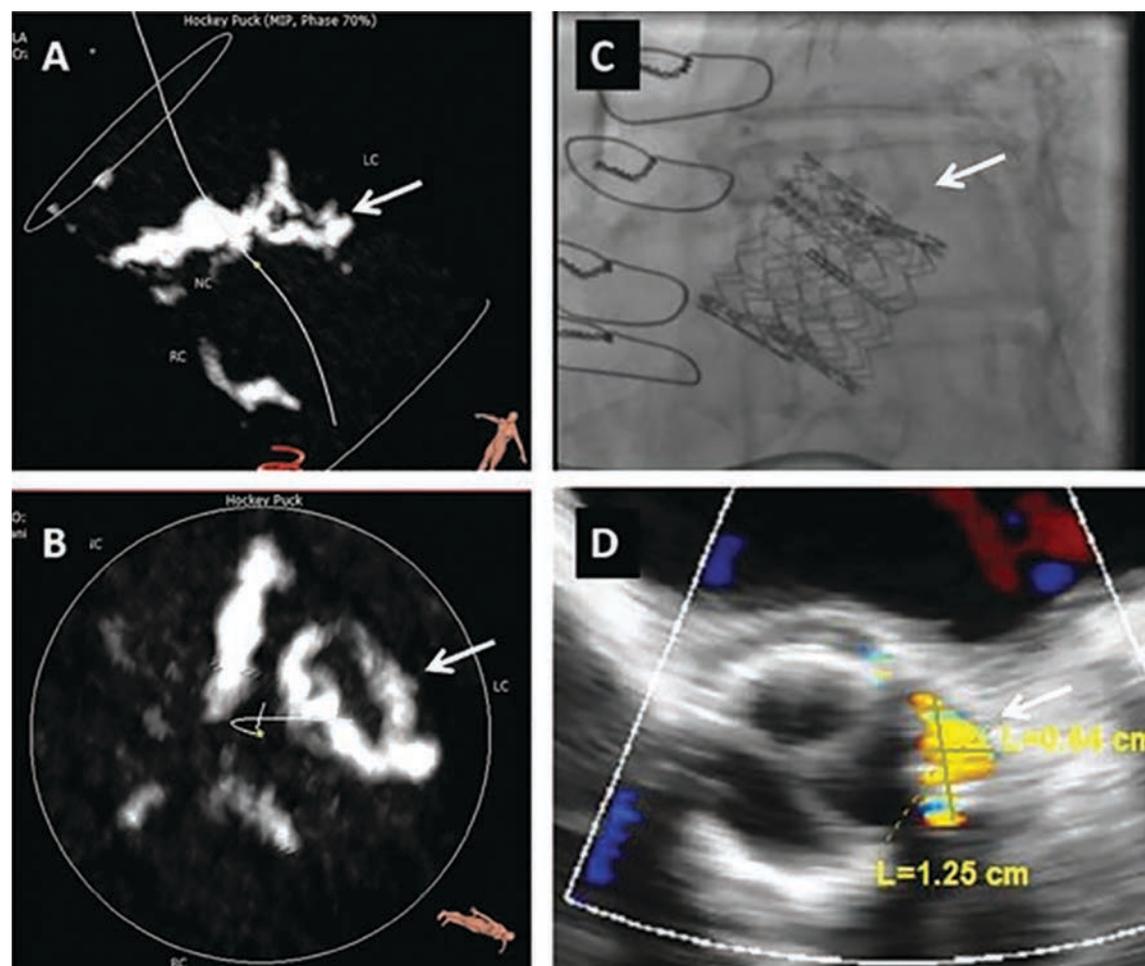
Transcatheter valve in transcatheter valve (TV-inTV) for paravalvular leak (PVL) caused by bulky calcium. (A, B) A preprocedural computed tomography revealed bulky calcium at the left coronary cusp corresponding to the PVL site. (C) TV-in-TV procedure was performed. The second valve (more ventricular) seemed to be slightly deformed at the calcification site; the position might also have been too ventricular for the device skirt to cover the PVL. (D) A follow-up transesophageal echocardiogram after TV-in-TV still showed the PVL (arrows indicate the location of calcification).
